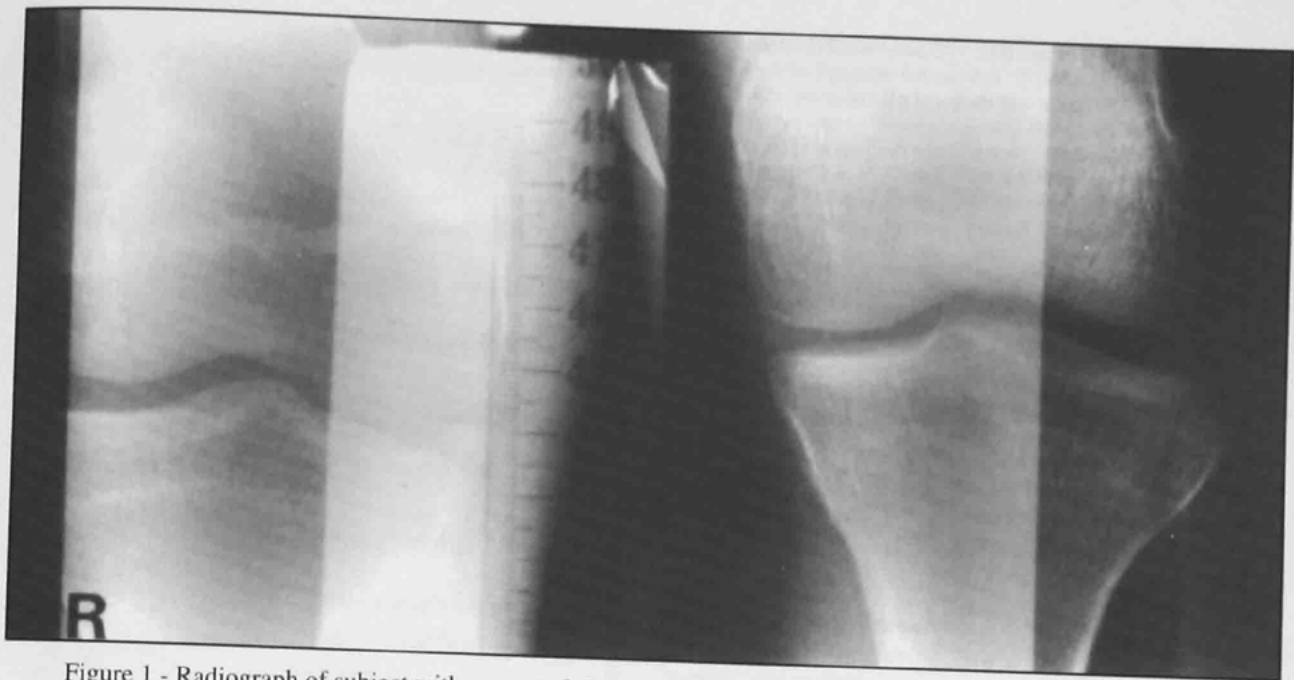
Radiograph of subject with suspected absence of ACL and PCL.
